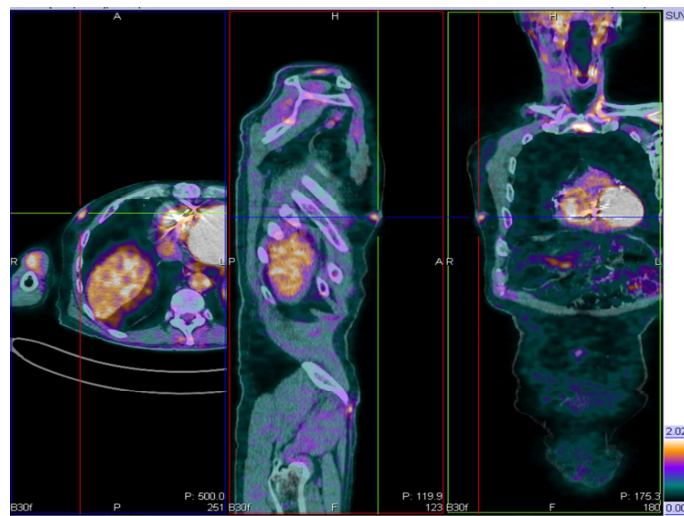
transaxial, sagittal and coronal 18F-FDG PET/CT images showing a focal uptake in right breast.
